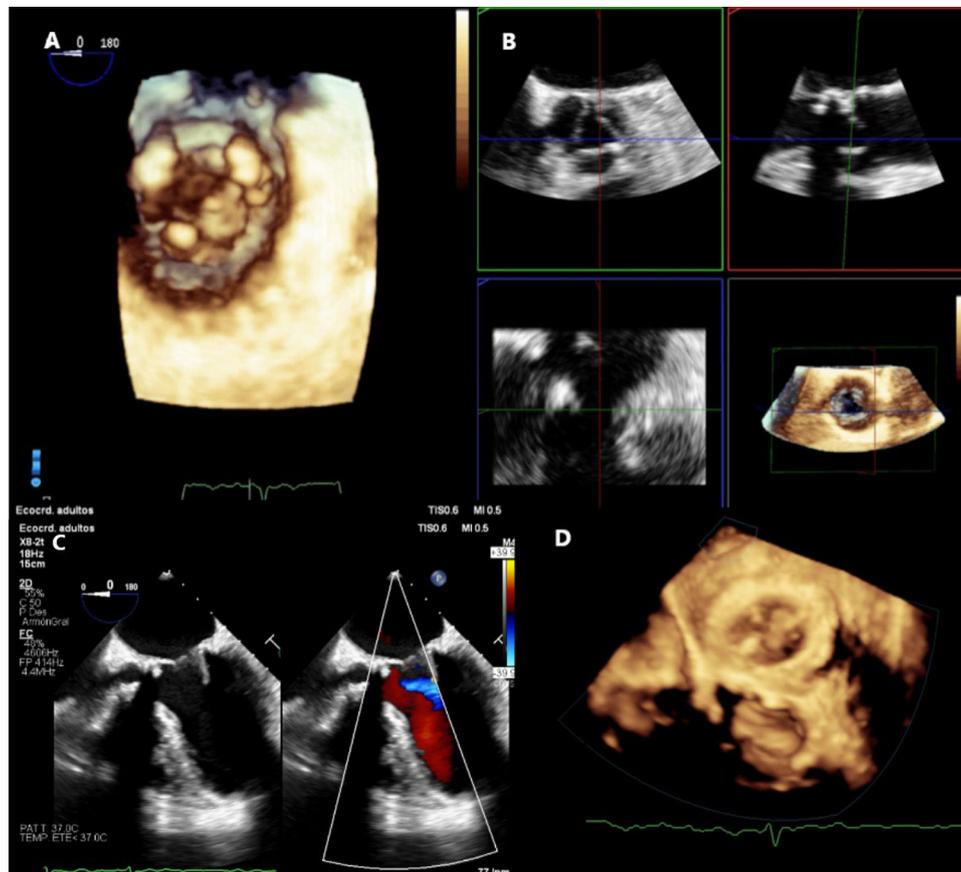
A: 3-dimensional transesophageal echocardiography (ventricular view) showing the lesion with a similar size. B: absence of native aortic valve involvement in orthogonal views. C: decrease in lesion size on transesophageal echocardiography at 0° with and without color. D: 3-dimensional transesophageal echocardiography; size of the lesion is smaller on the atrial side.
